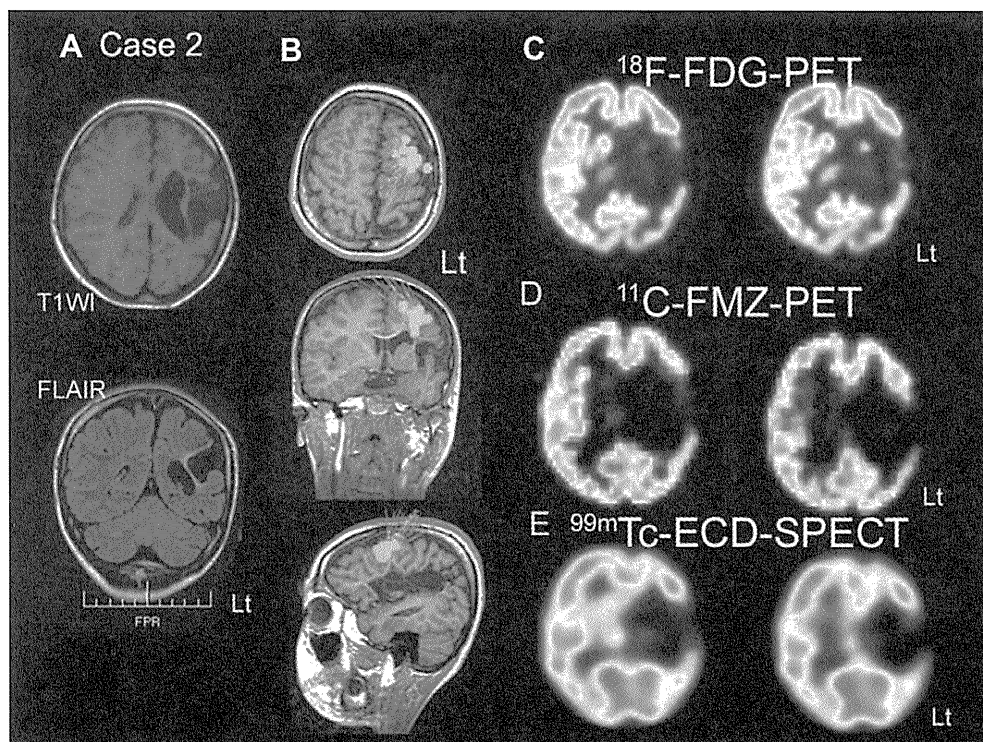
MRI, MEG, PET and SPECT of case 2. (A) Axial and sagittal MR images demonstrated a congenital middle cerebral artery stroke in the left hemisphere. (B) Equivalent current dipoles from MEG study with clustered spike source localization near a stroke lesion in the left frontal lobe (green dots). (C) [^{18}F]-fluorodeoxyglucose (FDG) positron emission CT (PET) showed hypofunctional glucose metabolism in the left frontal lobe. (D) [^{11}C]-flumazenil (FMZ) PET showed reduction of the benzodiazepine receptor binding in the left frontal lobe. (E) $^{99\text{m}}\text{Tc}$ -ethylcysteinate dimer (ECD) single photon emission CT (SPECT) showed hypoperfusion in the left frontal lobe.
